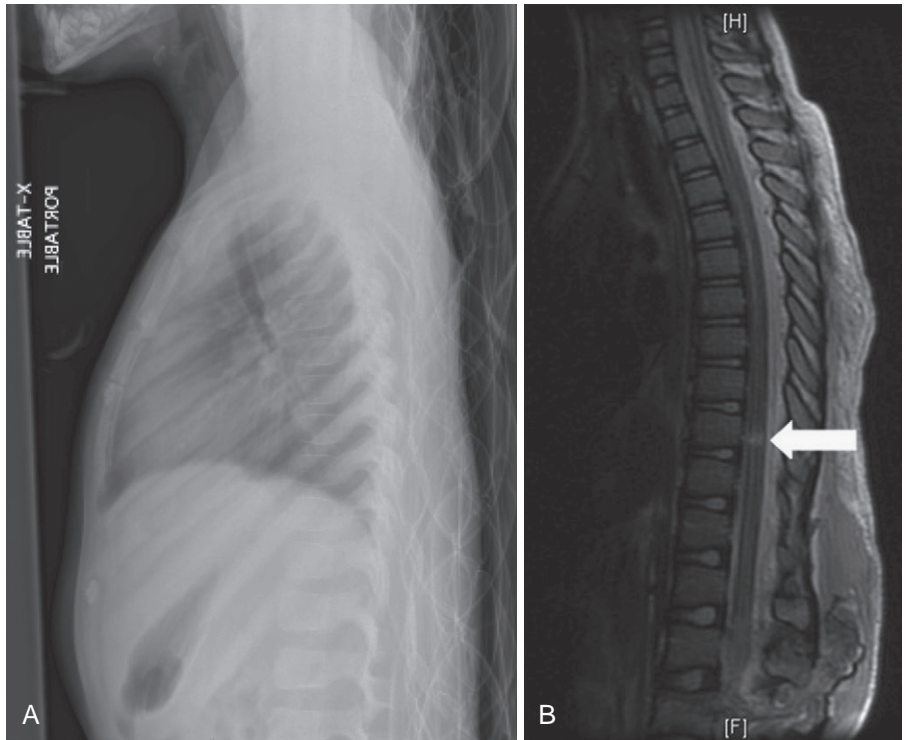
An example of spinal cord injury without radiographic abnormality (SCIWORA). The patient is a 6-year-old girl who, on neurologic examination, is a T10 complete paraplegic after a motor vehicle accident. A, Normal-appearing plain radiograph of the thoracic spine. B, Further workup with magnetic resonance imaging (MRI) shows cord signal change (white arrow) at the T10 level on the sagittal T2-weighted sequence, indicating a spinal cord injury without evidence of abnormality on the plain radiograph at the T10 level.
